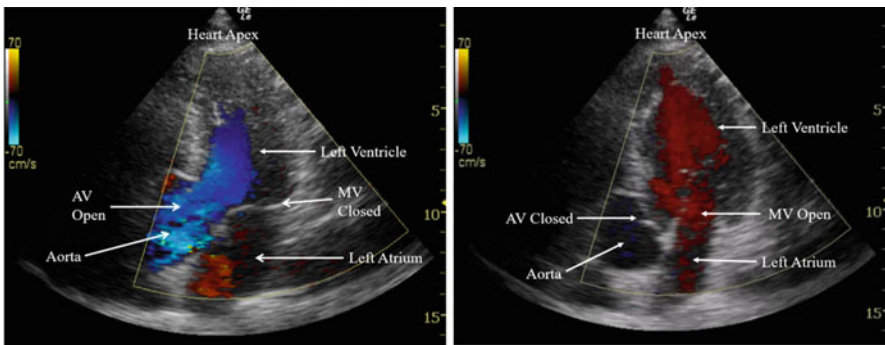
Apical 5 chamber view with color Doppler in systole (left panel) and diastole (right panel)
